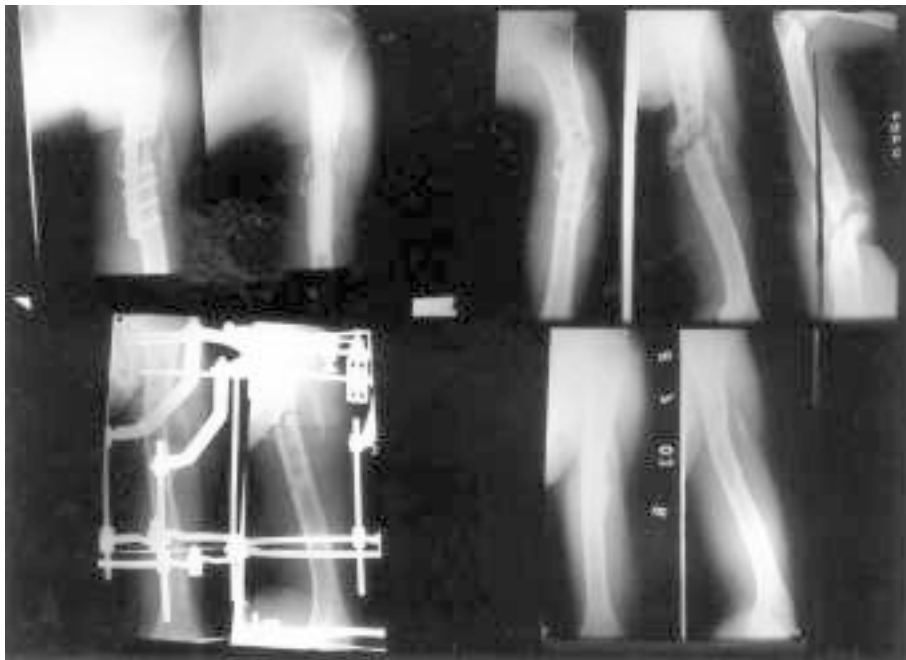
Combined photograph of a patient (AIM) showing radiographic appearance of a humeral nonunion with DCP fixation and bone grafting (A), following infection after removal of implants (B), with Ilizarov fixator (C) and after healing of nonunion and removal of fixator (D)
